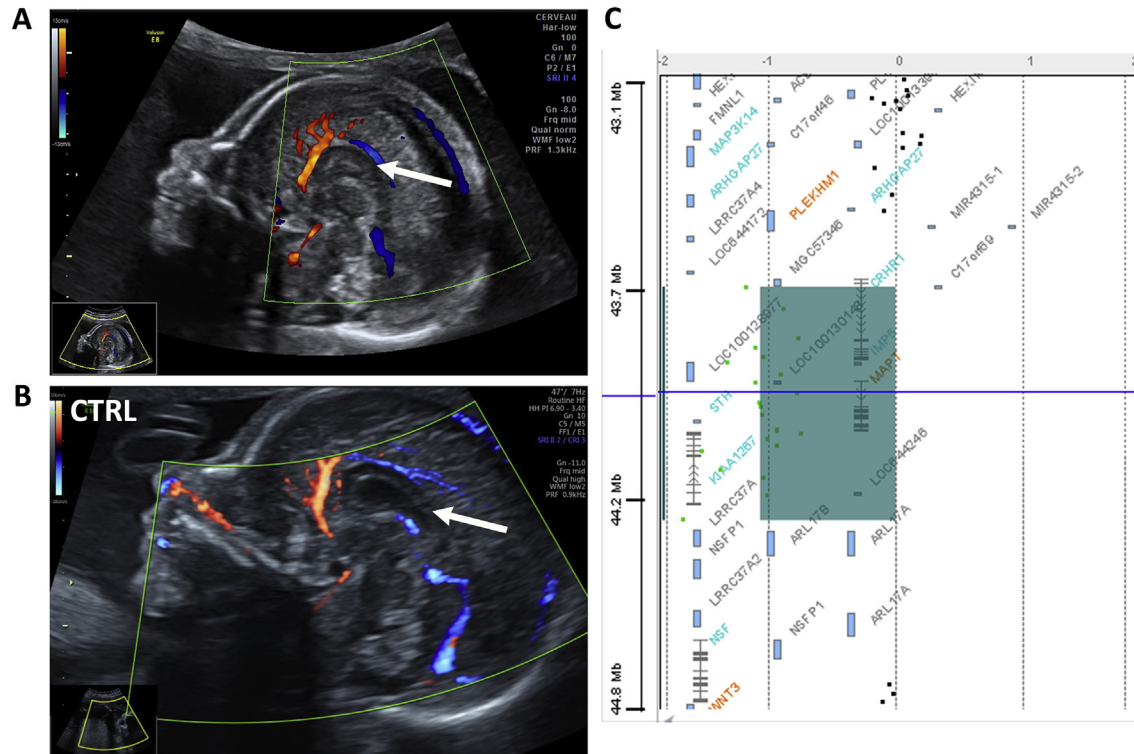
Brain ultrasound of the fetus and array-CGH profile.
